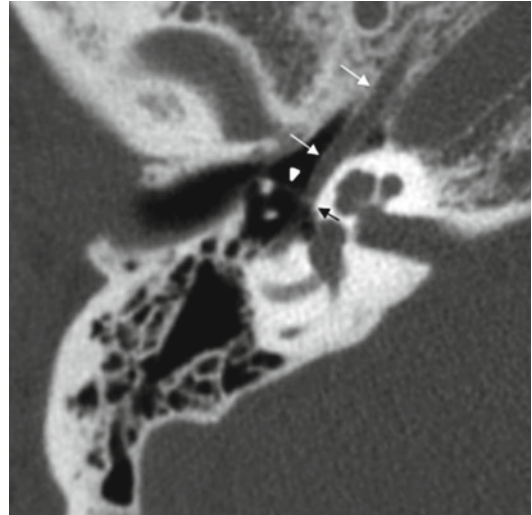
Transversal computed tomography of a right ear, showing the tensor tympani muscle in its bony semicanal (white arrows), reaching the cochleariform process (black arrow), where its tendon (white arrowhead) turns laterally to insert on the neck of the malleus
